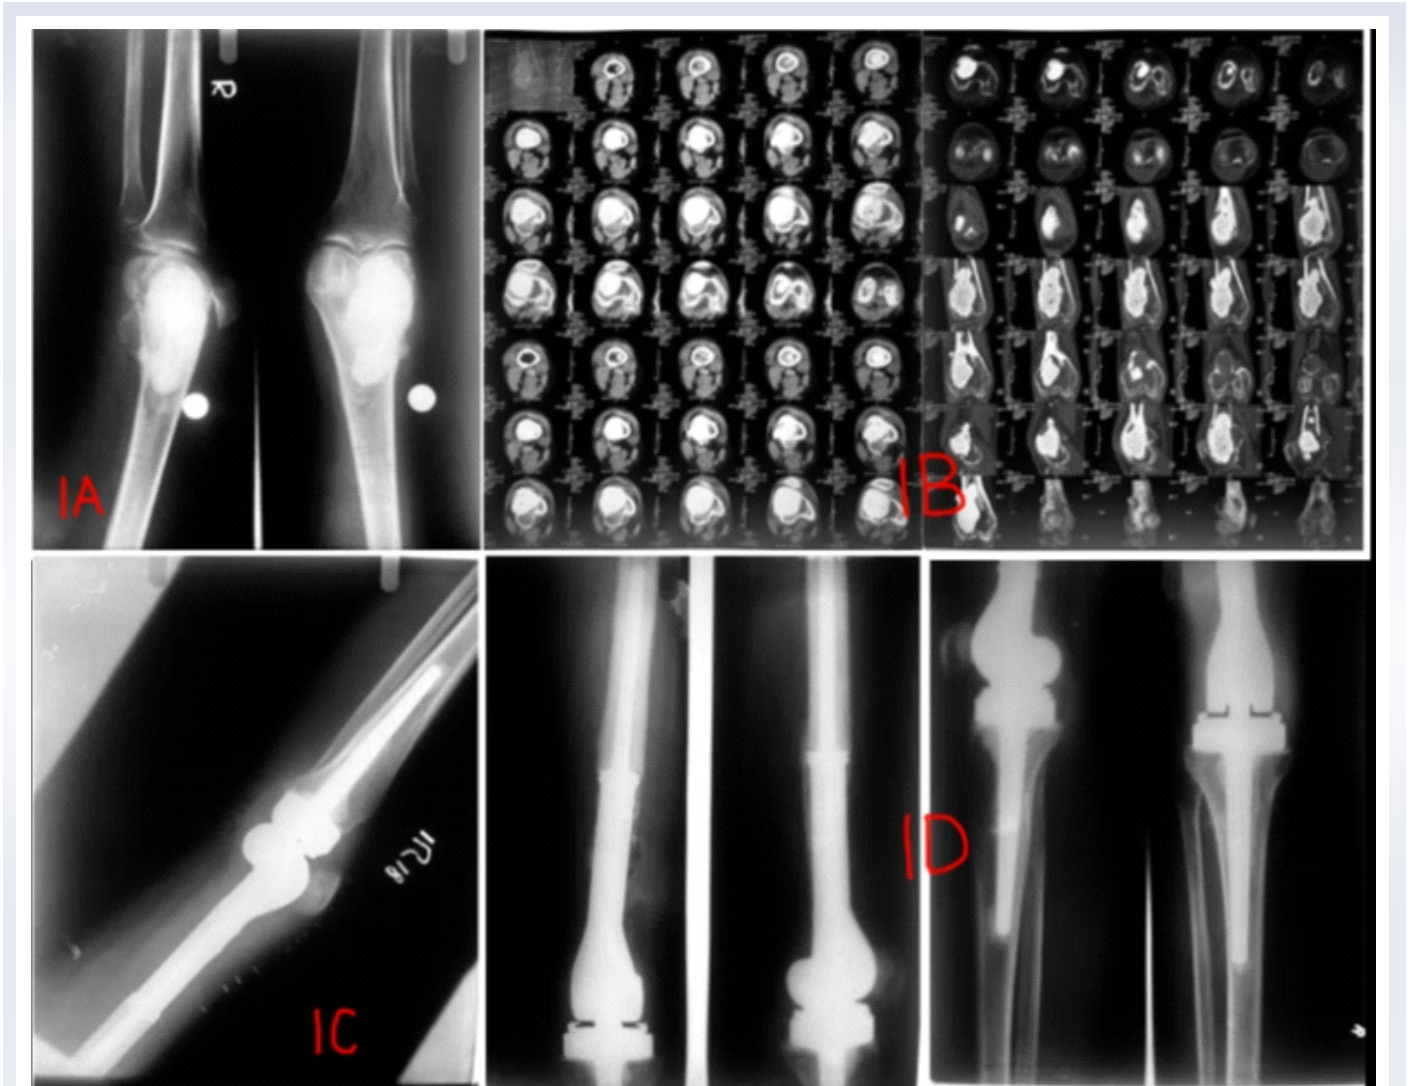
A male patient of age 35 years with distal femur recurrent GCT, which was treated with resection and megaprosthesis: (A) Radiograph showing extended curettage and bone cementing; (B) MRI of right distal femur; (C) Postoperative radiographs showing megaprosthesis; (D) Follow up X-ray at 10 years
